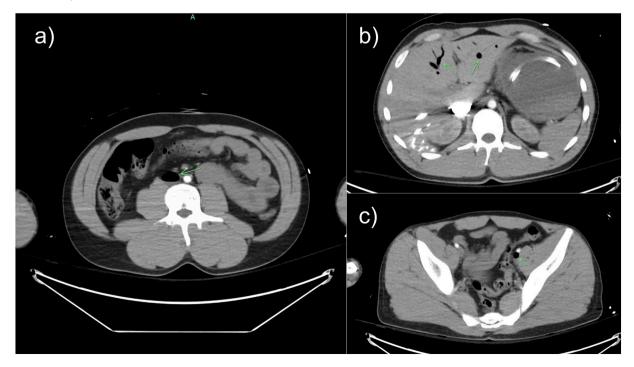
CT abdomen and pelvis with contrast showing air within the (a) inferior vena cava, (b) hepatic venous system, and (c) left external iliac vein.
